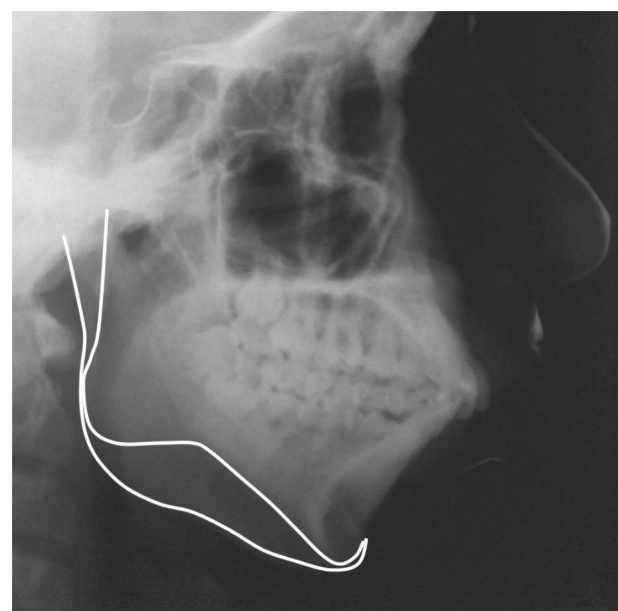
Identification of mandibular asymmetry on a lateral cephalometric radiograph.
